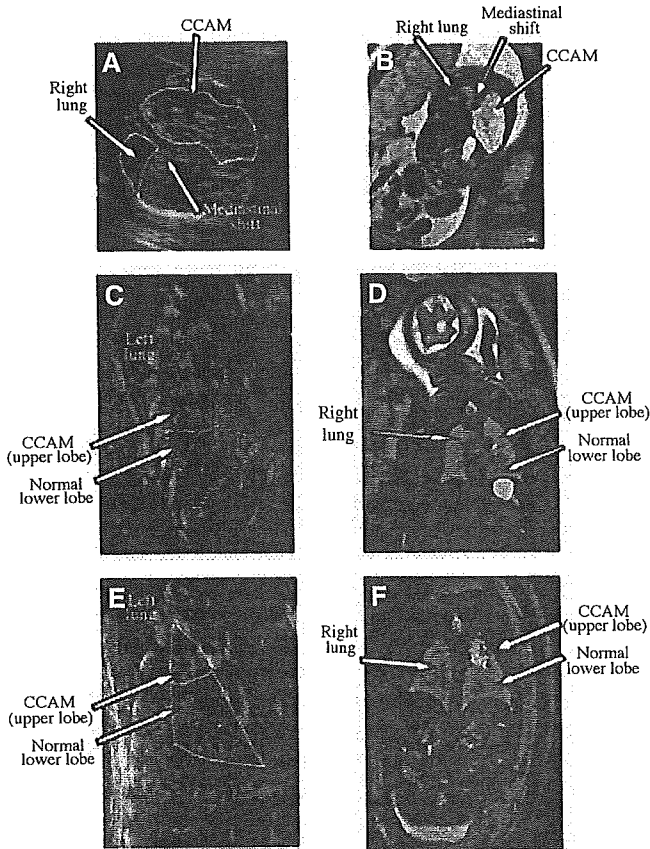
Ultrasound (A, C, E) and MR (T2-weighted, B, D, F) images at 24 (A, C), 30 (C, D), and 36 (E, F) weeks of gestation.
